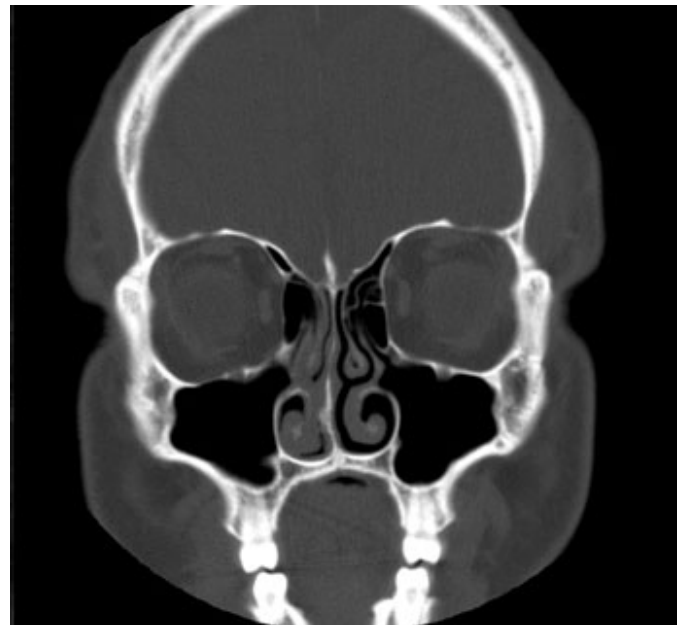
Coronal CT image of showing normal air-filled sinuses with no evidence of bone destruction or soft tissue masses.
